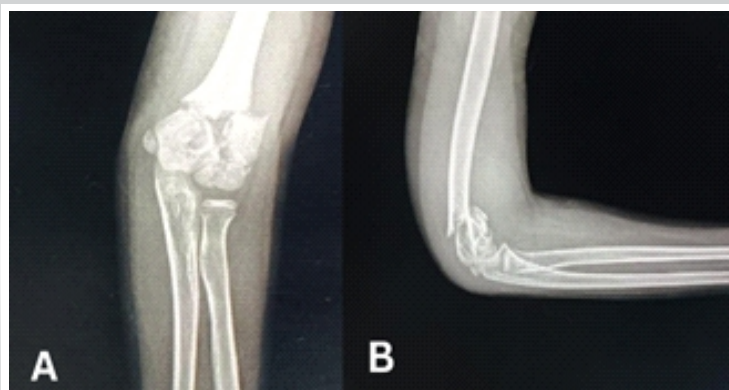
Immediate post-traumatic X-rays of right elbow (a) anteroposterior view, (b) lateral view.
